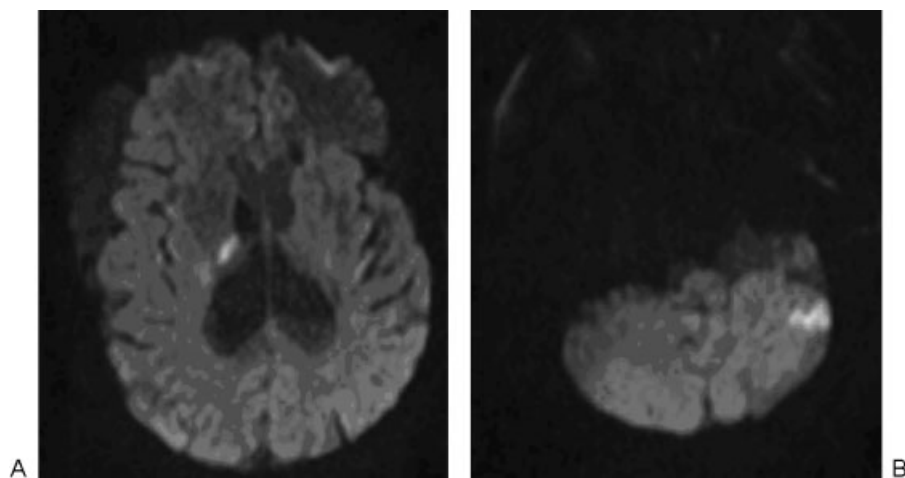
Axial diffusion-weighted magnetic resonance imaging of the brain on postoperative day 9 demonstrating infarcts of (A) right corona radiata and (B) left lateral cerebellum.
